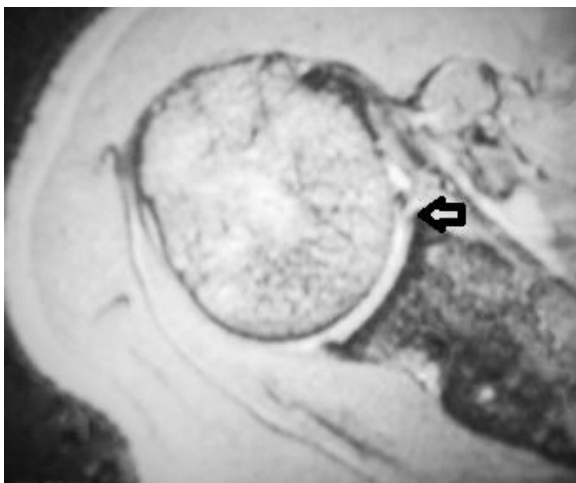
CT arthrogram of the shoulder displays a loose body in the axillary recess.
